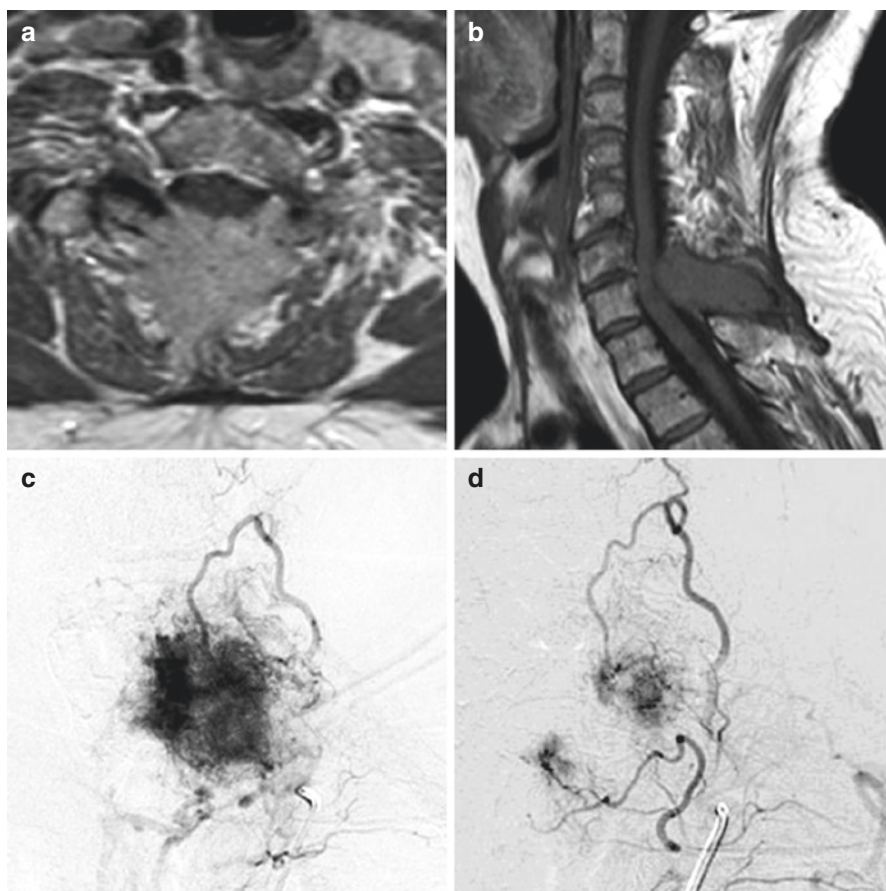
Seventy-four-year-old woman with renal carcinoma's metastasis in C7 undergoing a preoperative endovascular treatment. Post-contrast axial T1-weighted (a) and sagittal T1-weighted (b) images show involvement of the posterior arch by the metastasis with compression of the spinal cord. DSA AP view (c) demonstrates the high vascularization of the lesion fed by branches of both the tiro-cervical trunks. AP angiogram (d), immediately after the embolization with PVA particles, shows a consistent reduction of blood supply in the lesion
